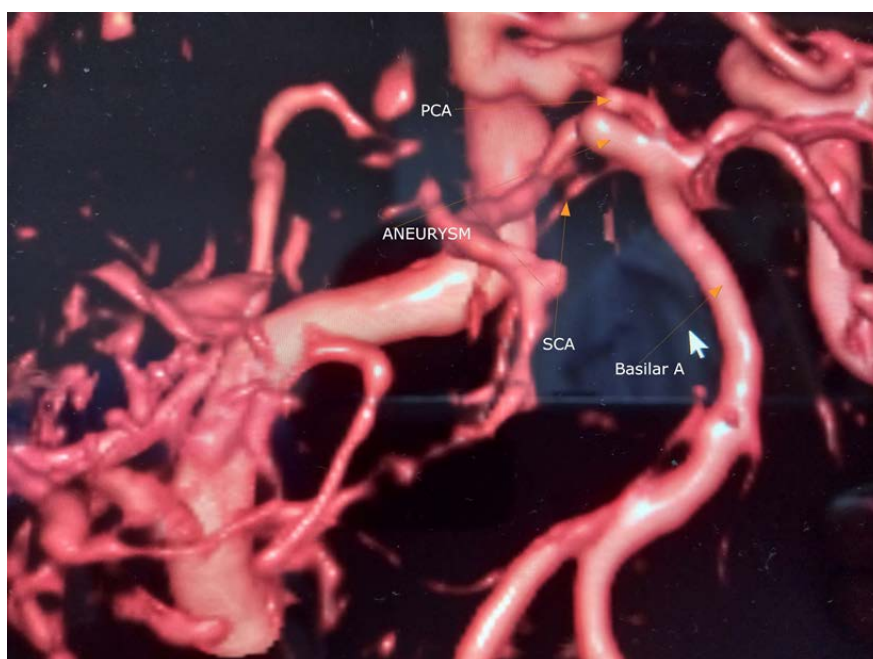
CTA of superior cerebellar aneurism.
